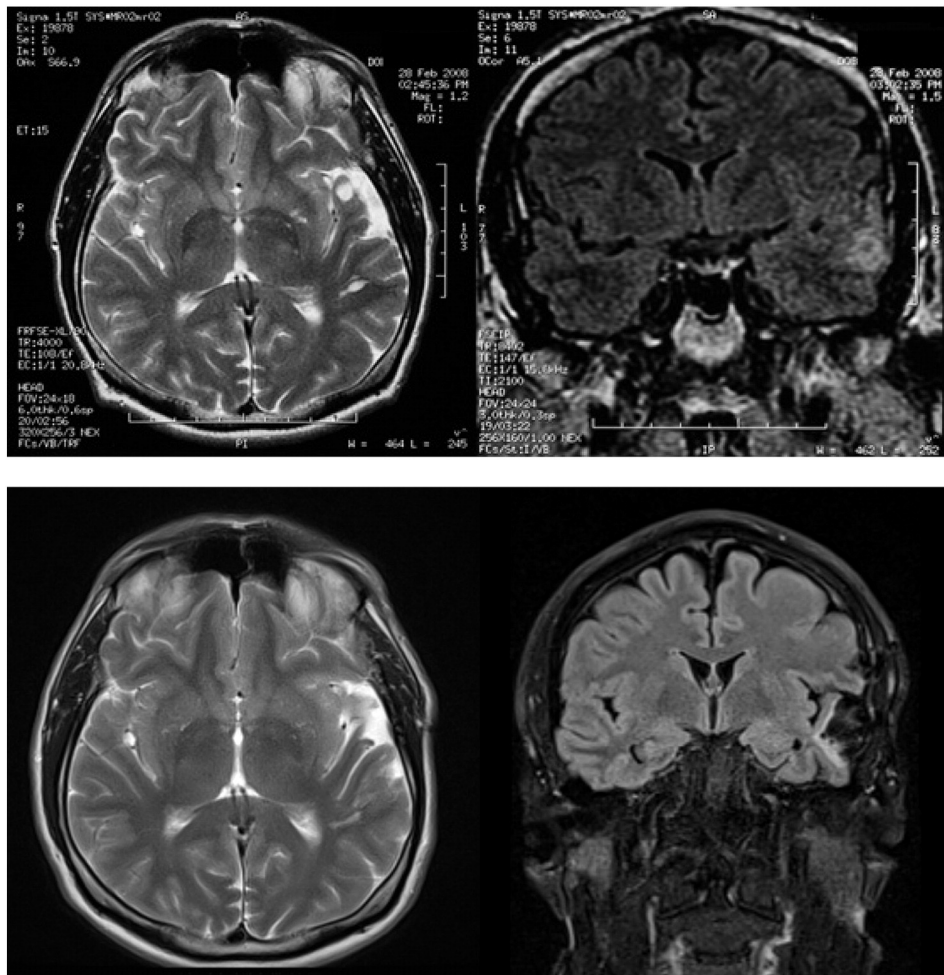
Structural MR images (axial T2 and coronal FLAIR) of the left temporal lesion preoperatively (top) and after surgery (bottom) in case A.
